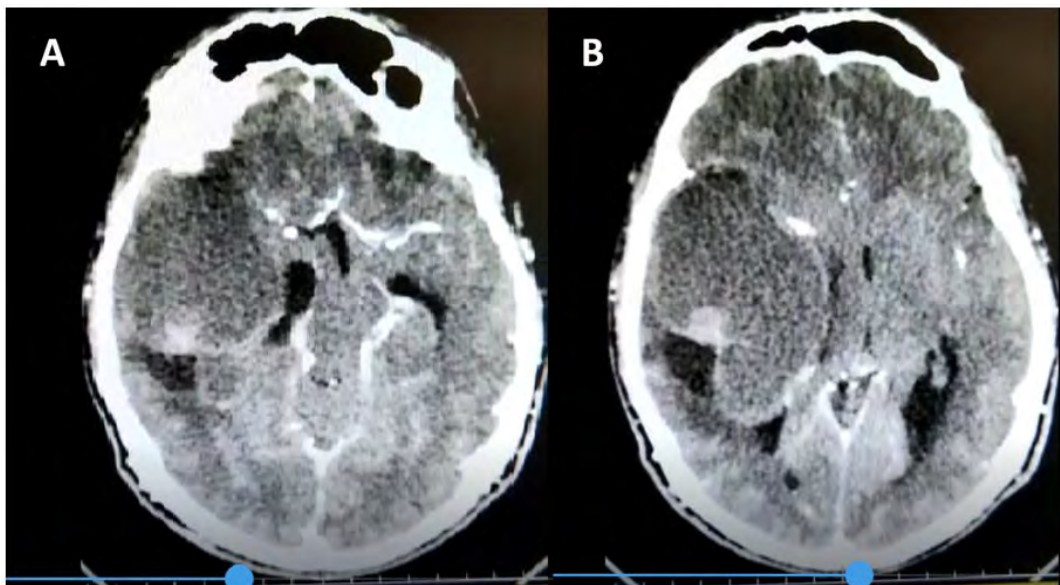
A, B. Pre-operative CT. Axial view.
